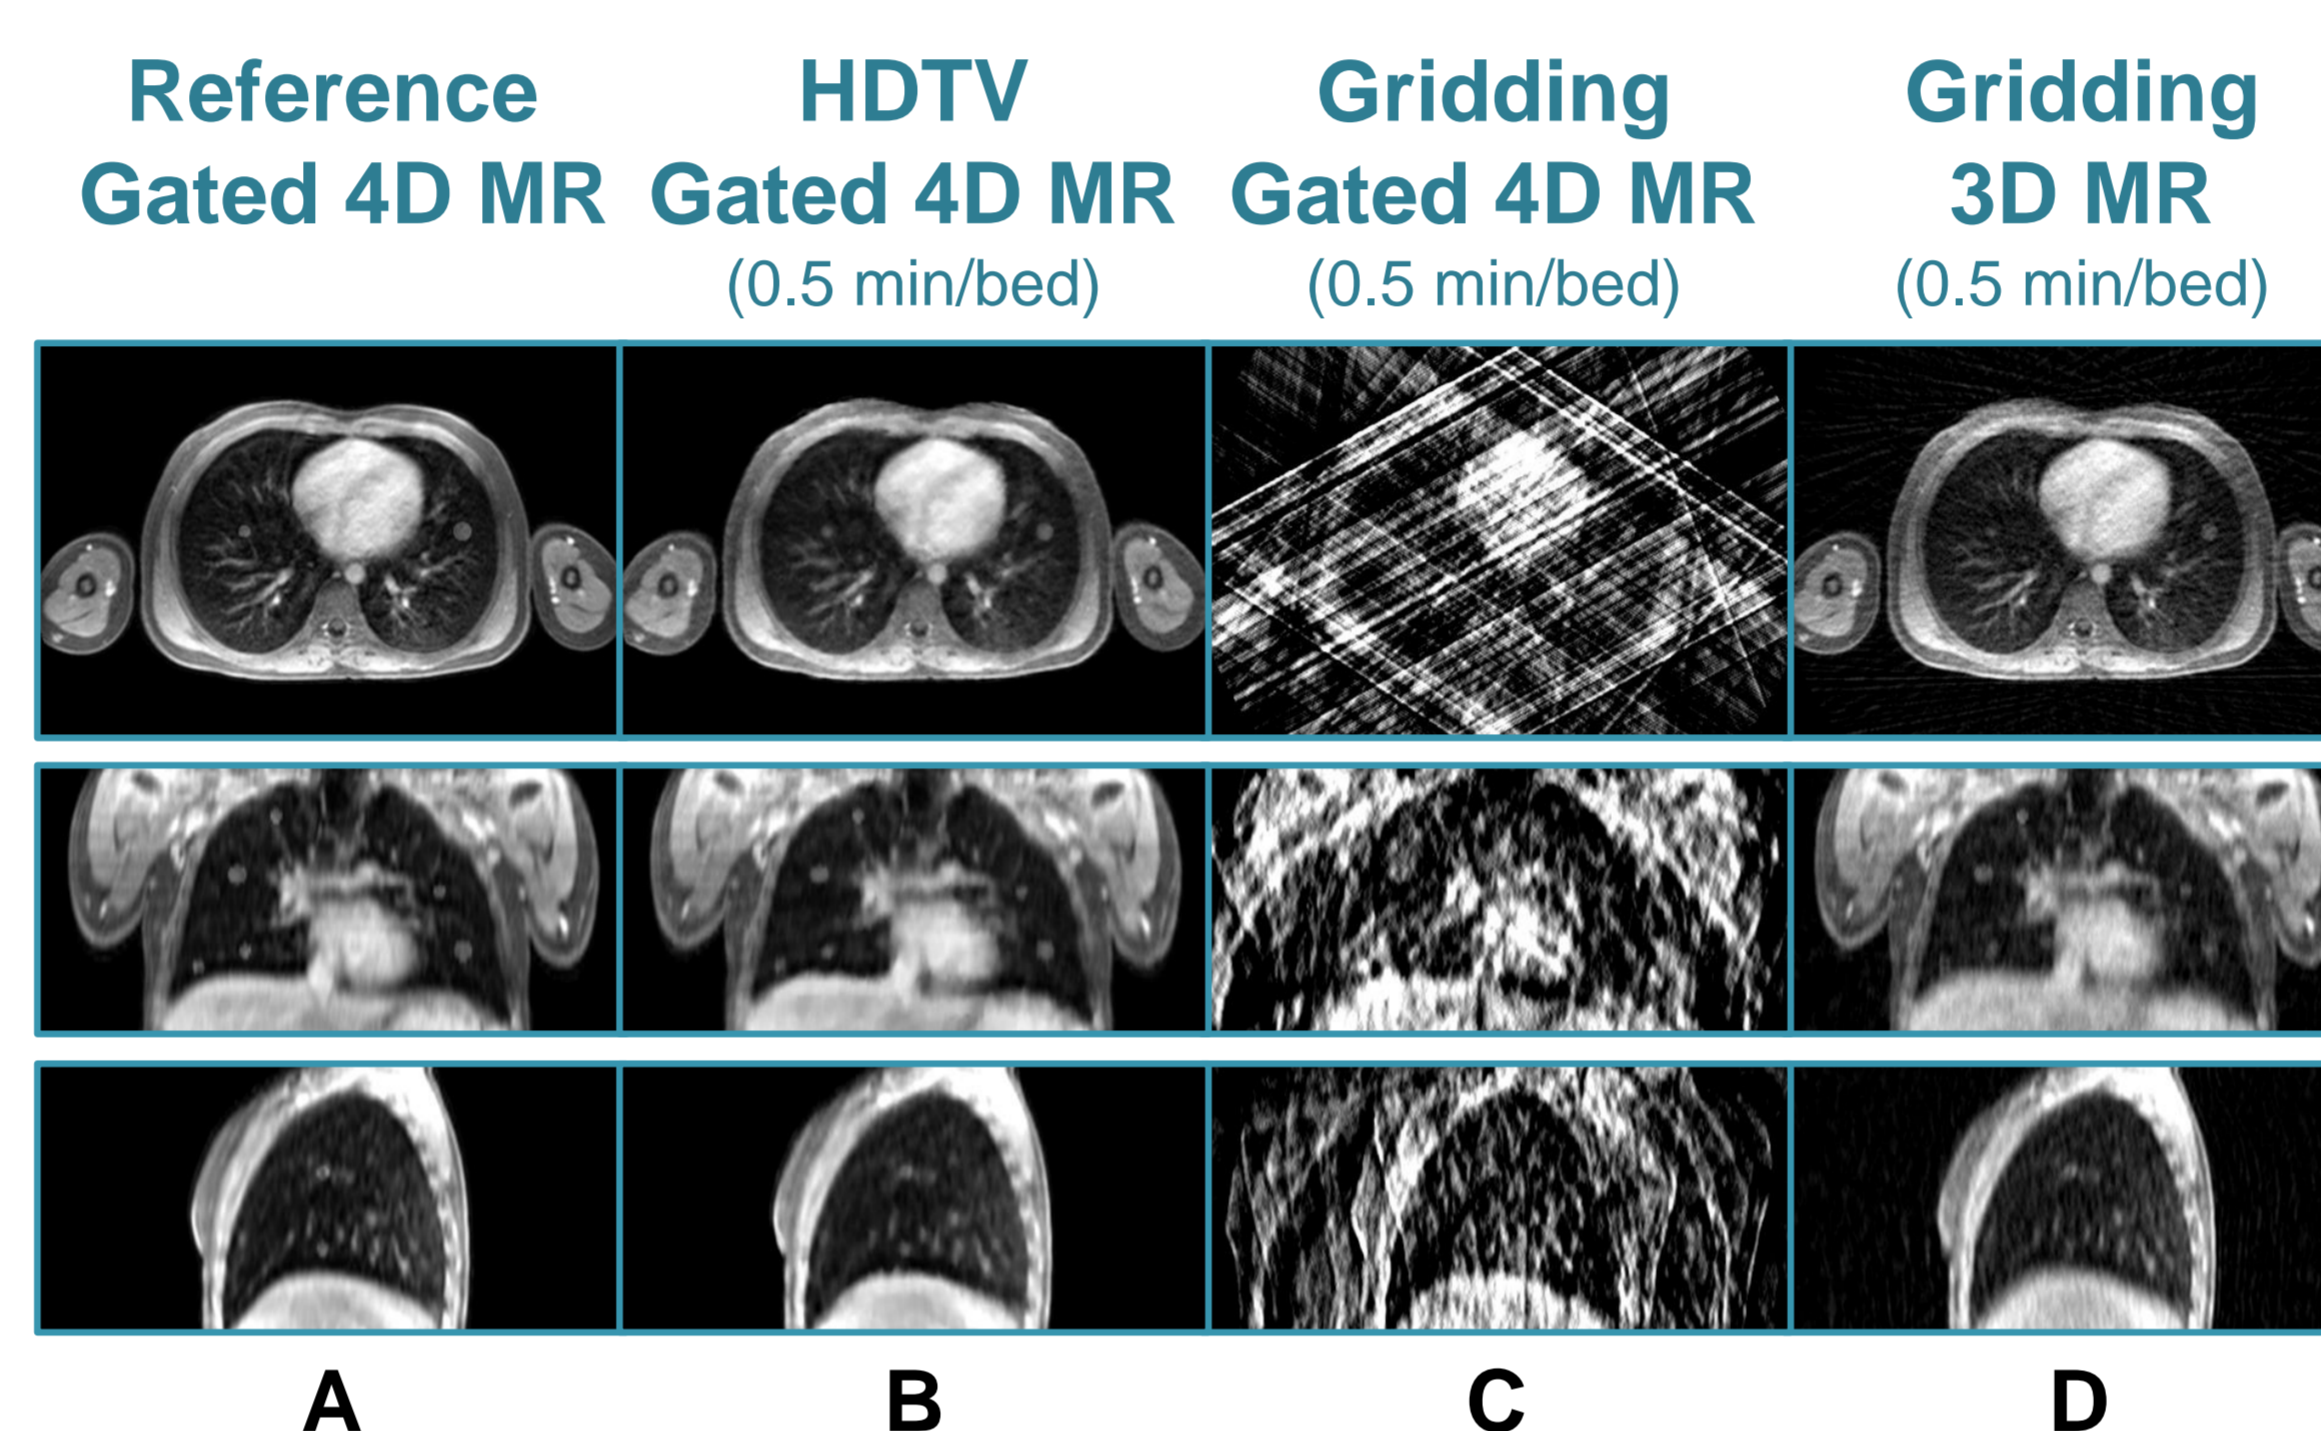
Comparison of MR image reconstructions
